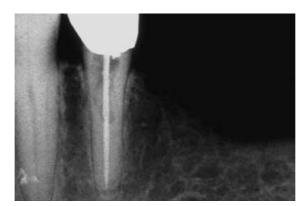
Final radiograph taken after obturation of the root canal.
